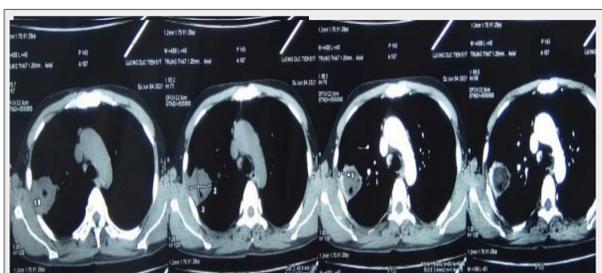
51-year-old male patient with a history of M4 Leukemia. His CT scan found an abnormal mass 27 x 36 mm with cavity on the right upper lobe, multiple nodes bilateral. The diagnosis were concluded by lung biopsy.
